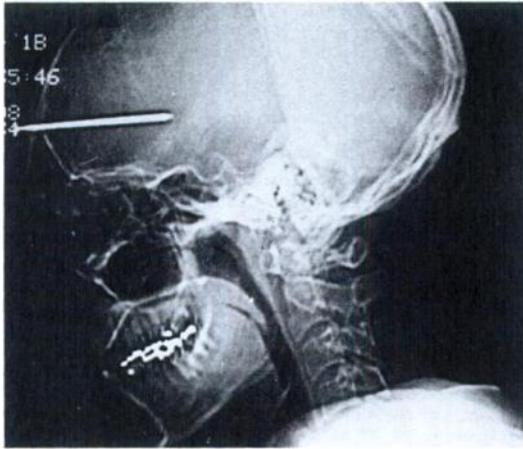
Lateral skull radiograph showing the nail *in situ*
